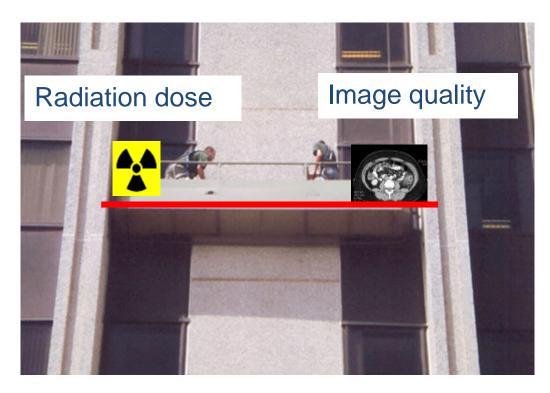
Image Quality in CT gets better and better with more dose
